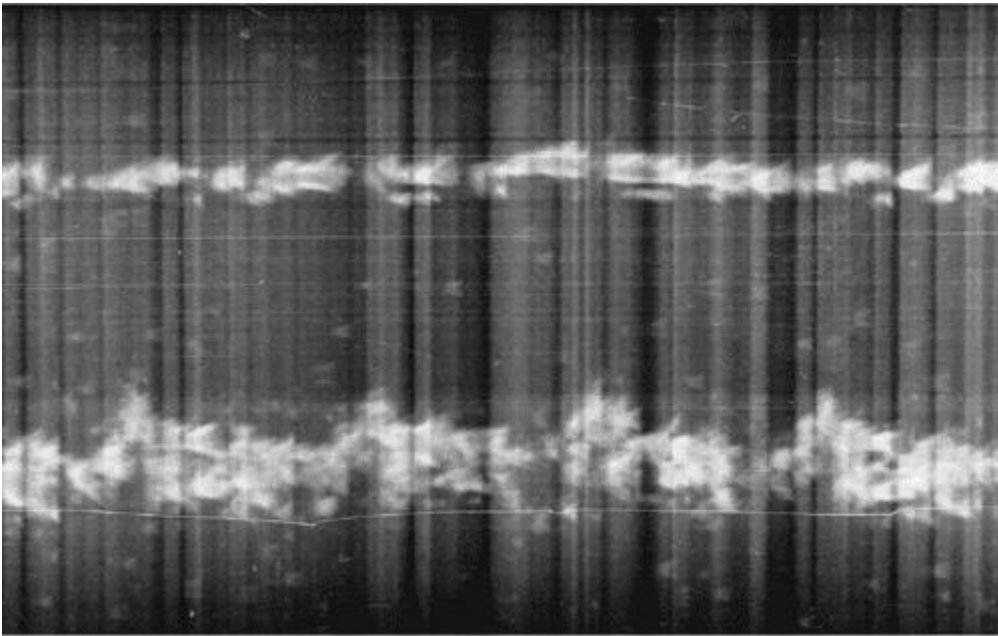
The first echocardiographic recording obtained by Inge Edler and Hellmuth Hertz, displayed as an
